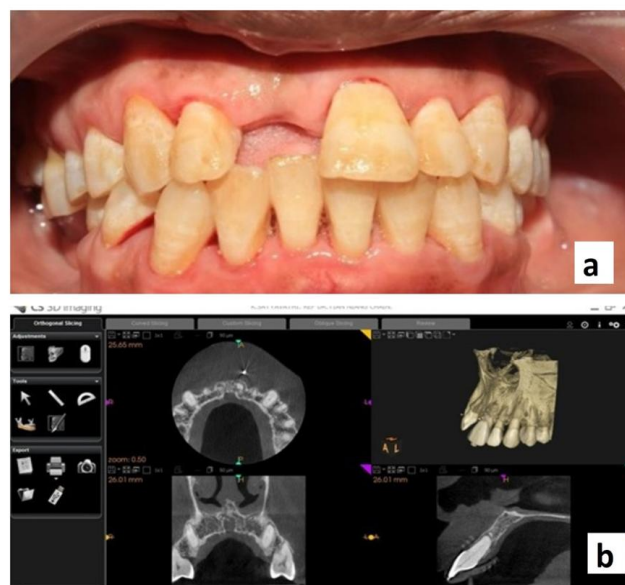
(a) Preoperative clinical view (b) Preoperative CBCT
